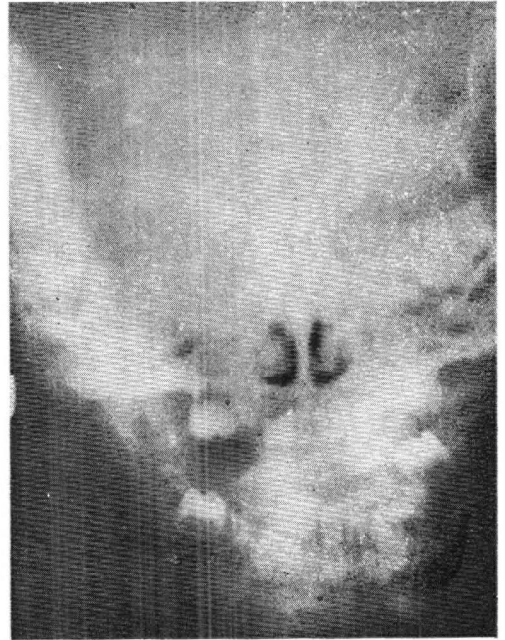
X-Ray both jaws and skull - showing 5 teeth in the upper jaw and 8 in lower jaw.
